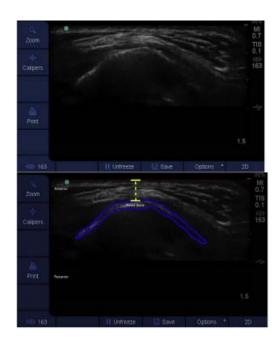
ULTRASONOGRAPHY OF THE ANTERIOR NECK SOFT TISSUE THICKNESS - DSHB
